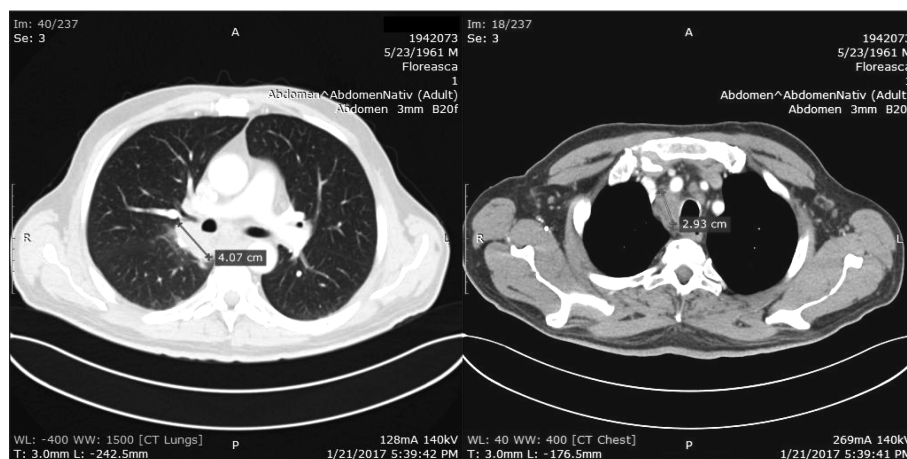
CT scan of the retrohilar pulmonary mass and the mediastinal adenopathies.
